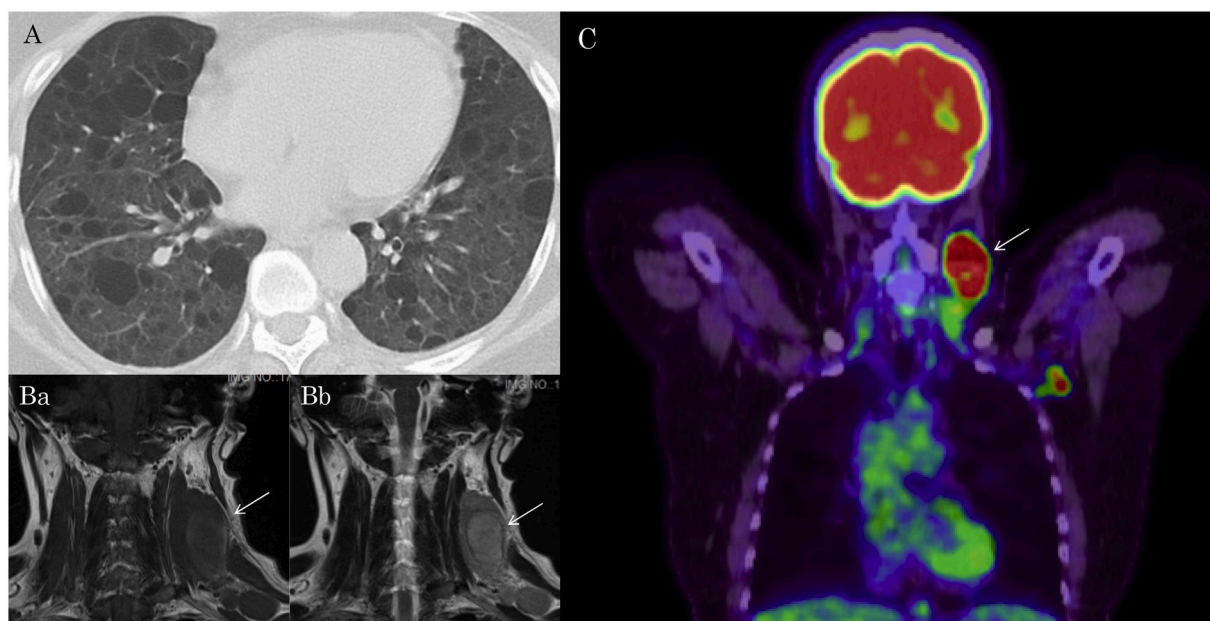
Radiographic images of this case. (A) Chest CT finding. Diffuse thin-walled cysts are typical features of LAM. (B) Magnetic resonance images of the neck mass. The well defined mass (arrow) was hypointense in T1-weighted sequences (a) and hyperintense in T2-weighted sequences (b). (C) ^{18}F -fluorodeoxyglucose-positron emission tomography. Abnormal uptake was observed at the mass (arrow).
